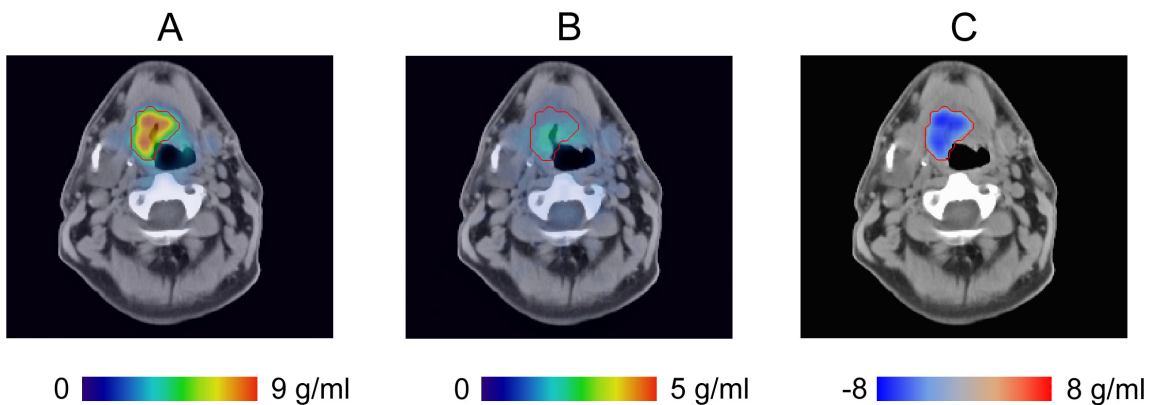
Deformable registration applied to PET images. A) Baseline PET/CT with ROI, B) Deformed post-treatment PET/CT with ROI, C) SUV differences inside ROI.
